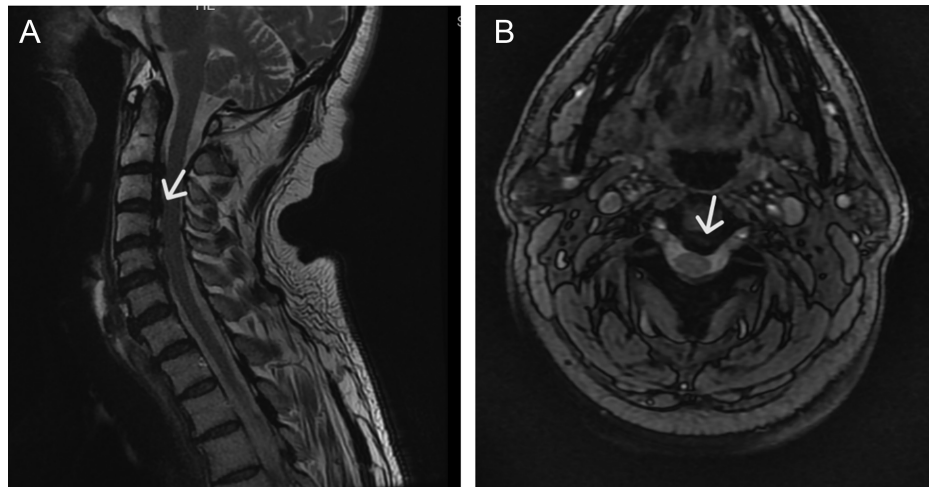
(A) On T2-weighted images, hypointense osteophytes are observed in the posterior corners of 4 consecutive vertebral bodies, and disc spaces are preserved in the sagittal section. (B) In addition, erasure of the anterior subarachnoid space and contact with the spinal cord is observed in the axial section.
